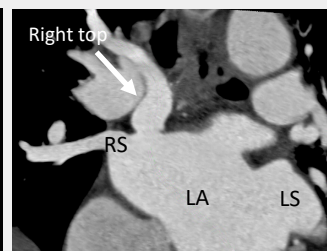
Coronal reformatted CT image showing extra right top PV, inserts medial and superior to RSPV.
